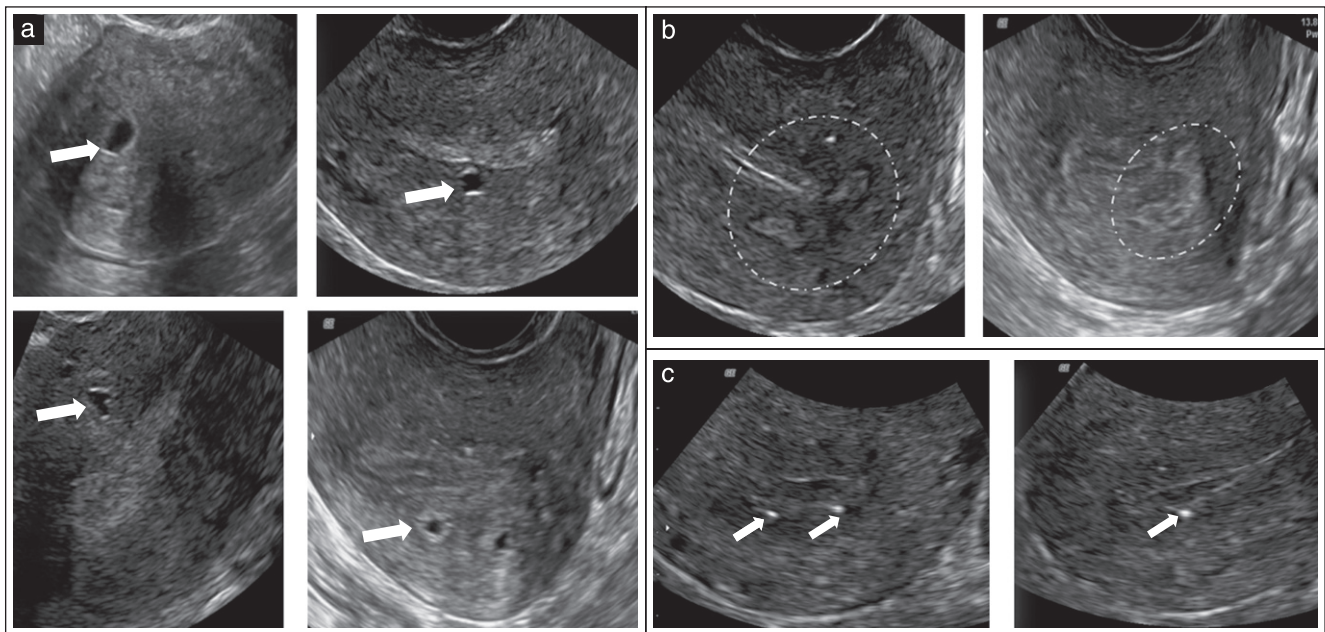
Ultrasound images showing: (a) myometrial cysts (arrows); (b) hyperechogenic islands (surrounded by dotted lines); and (c) echogenic spots (arrows).
